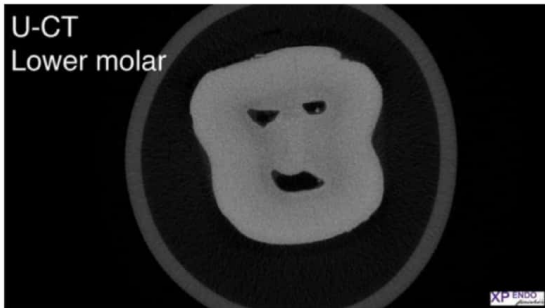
CBCT cross section of a mandibular molar in the mid-root area. None of the canals are round
